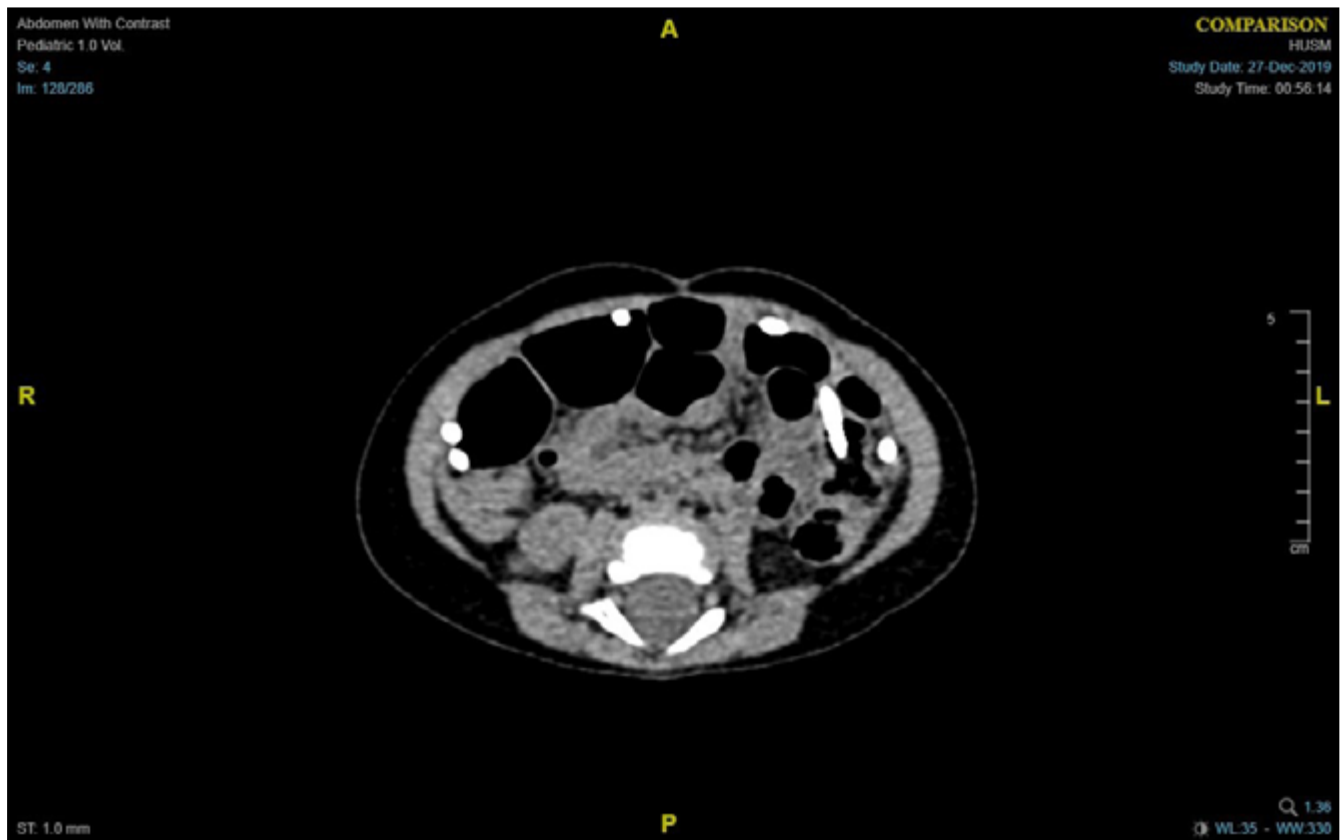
CT Abdomen showed the distal peritoneal catheter entering mid descending bowel.
